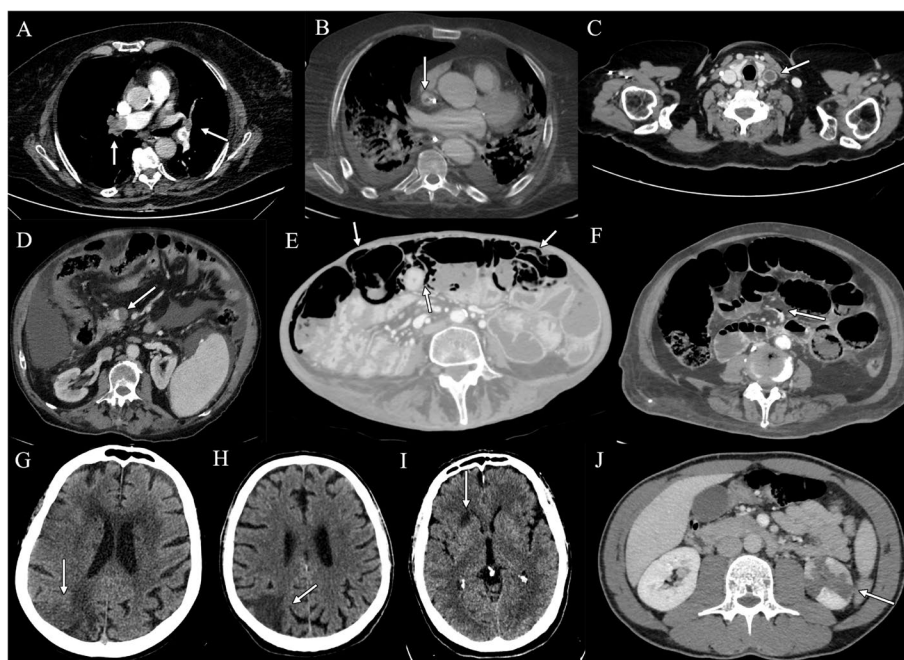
Axial contrast-enhanced CT images patients infected with SARS-CoV-2 virus admitted to ICU demonstrating filling defects indicative of thromboembolic complications: a massive and multiple lung embolism in the right and the left pulmonary arteries (arrows in A), partial thrombosis of the superior vena cava caused by the placement of a peripherally inserted central venous catheter (arrow in B) and complete thrombosis of the left jugular vein (arrow in C). Axial contrast-enhanced CT scan of a severely ill COVID-19 patient demonstrating a partial filling defect in the superior mesenteric vein (arrow in D); axial contrast-enhanced CT scan of the same patients performed after 4 days showing the appearance of gas in intramural space of the dilated small bowel walls referable to pneumatosis intestinalis (arrows in E) and mesenteric intra-venous gas (arrow in F). Axial contrast-enhanced CT images of several patients admitted to ICU due to severe COVID-19 infection demonstrating an acute ischemic stroke in the right parietal lobe (arrows in G and H) and at the level of basal ganglia (arrow in I). Axial contrast-enhanced images of a COVID-19 patient with multiple triangle-shaped hypointense areas at the inferior pole of the left kidney, referable to renal infarctions (arrow in J)
